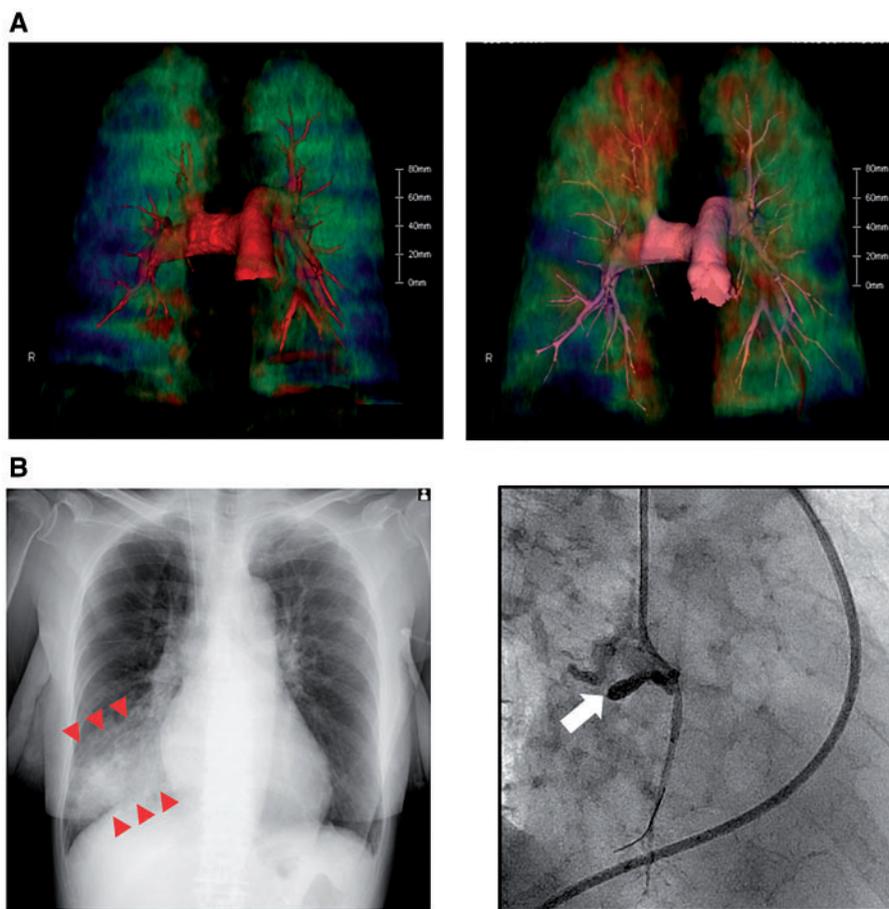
Representative images of major complications of BPA. (A) Fusion images of 3D-reconstructed pulmonary angiography and pulmonary perfusion images derived from dual-energy computed tomography in a chronic thrombo-embolic pulmonary hypertension patient before (left) and after (right) balloon pulmonary angioplasty (BPA). Lung field in blue and red indicates low and normal pulmonary perfusion area, respectively. In this patient, mean pulmonary arterial pressure was decreased from 43 mmHg to 19 mmHg after four sessions of BPA. (B) (Left) Chest X-ray on the day of BPA showing segmental pulmonary oedema at the right lower lung field (red arrowheads). In this patient, BPA was performed to the pulmonary artery of the right lower lobe. (Right) Selective pulmonary angiography showing pulmonary arterial dissection at the pulmonary artery segment of the left lower lobe after BPA (white arrow).
